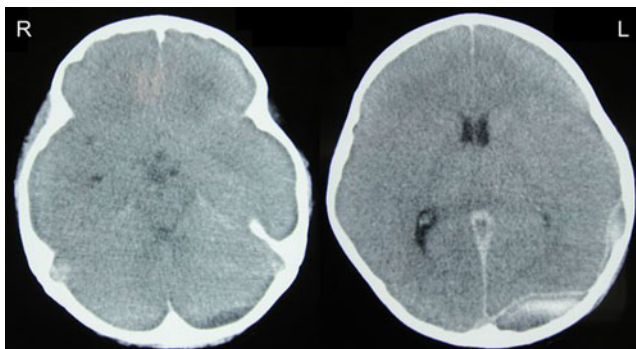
Postmortem cranial CT reveals a subacute epidural haematoma expanding over the left occipital region and left posterior cranial fossa. The perimesencephalic cisternae tend to be obliterated, and the left inferior horn of lateral ventricle is completely compressed due to the epidural haematoma, which indicates intracranial hypertension
